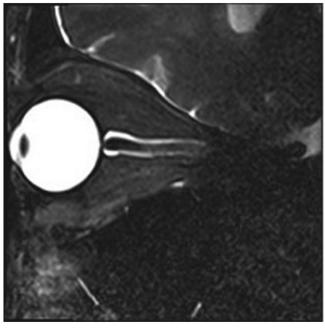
Sagittal T2-W1. Sagittal section of the orbit showing normal optic nerve without ONT preflight; not an intra-astronaut pre- to postflight comparison. MRI image provided by the Lifetime Surveillance of Astronaut Health (LSAH) Program, NASA Johnson Space Center.
